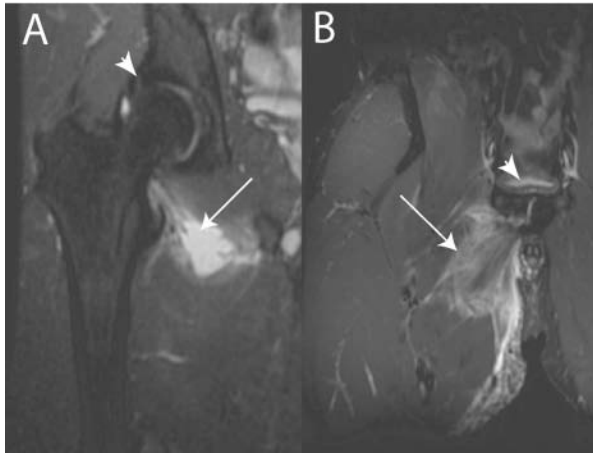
The sports hip triad. Athletes with hip pain often present with a characteristic combination of injuries about the hip. A, MRI demonstrating a labral tear with proximal muscle injury. Images were obtained using coronal inversion recovery and axial fast spin-echo body coil images, as well as high-resolution surface coil images of the right hip. There is evidence of right adductor magnus injury with a defined fluid collection of approximately 5 cm in the anterior aspect of the adductor magnus (arrow). There is also evidence of an anterior labral tear that begins at its base and extends through a fissure through the base of the superior labrum (arrowhead). B, coronal fast spin-echo MRI of the right groin in a National Football League running back with persistent groin pain. There is injury to the adductor tendon origin from the pubic symphysis (arrow), as well as degenerative changes of the pubic symphysis with insertional tendinosis of the rectus insertion (arrowhead).
